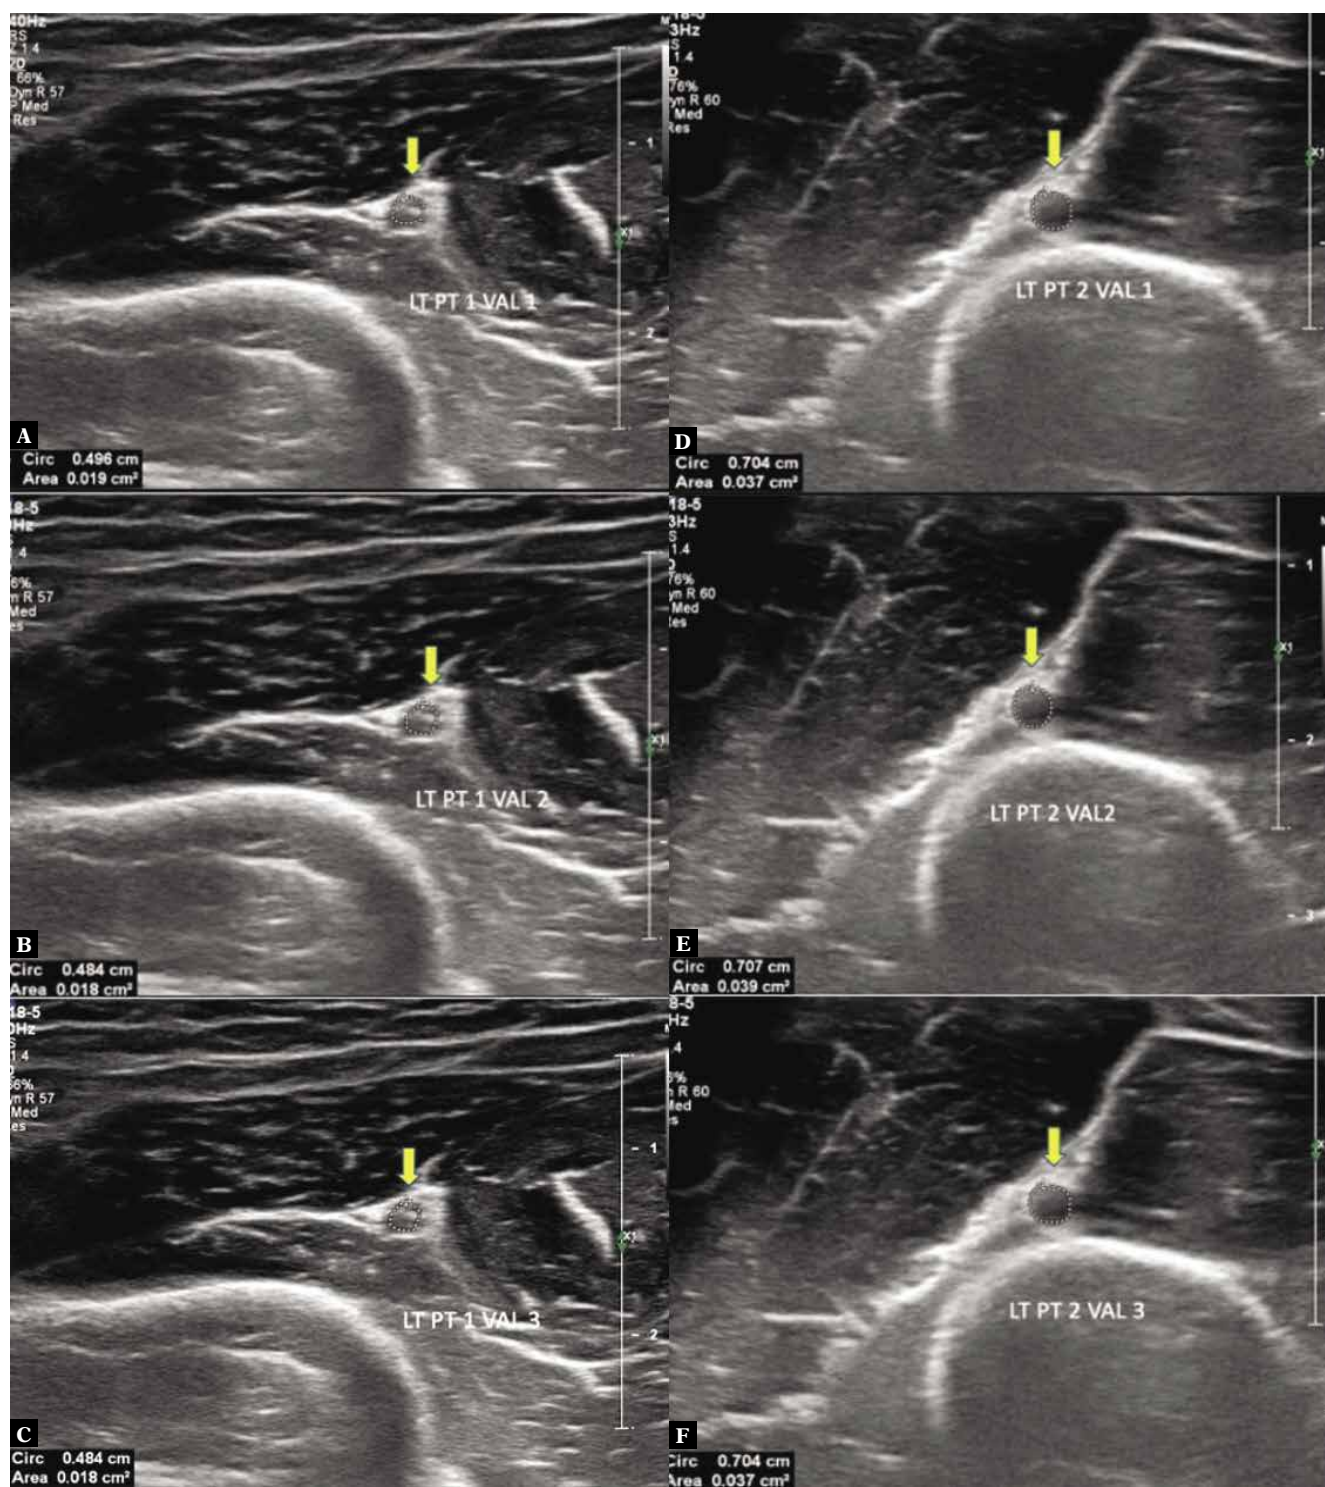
Ultrasonographic cross-sectional area values of the normal radial nerve (arrows) of the left upper limb in the axial plane at level 1 (A, B, C) and level 2 (D, E, F) in a 21-year-old male weighing 55 kg, with a height of 154 cm and a body mass index of 23.2 kg/m². The mean cross-sectional areas at level 1 and level 2 are 1.8 mm² and 3.8 mm², respectively (yellow arrow – radial nerve, RT – right, LT – left, PT – point, VAL – value)
